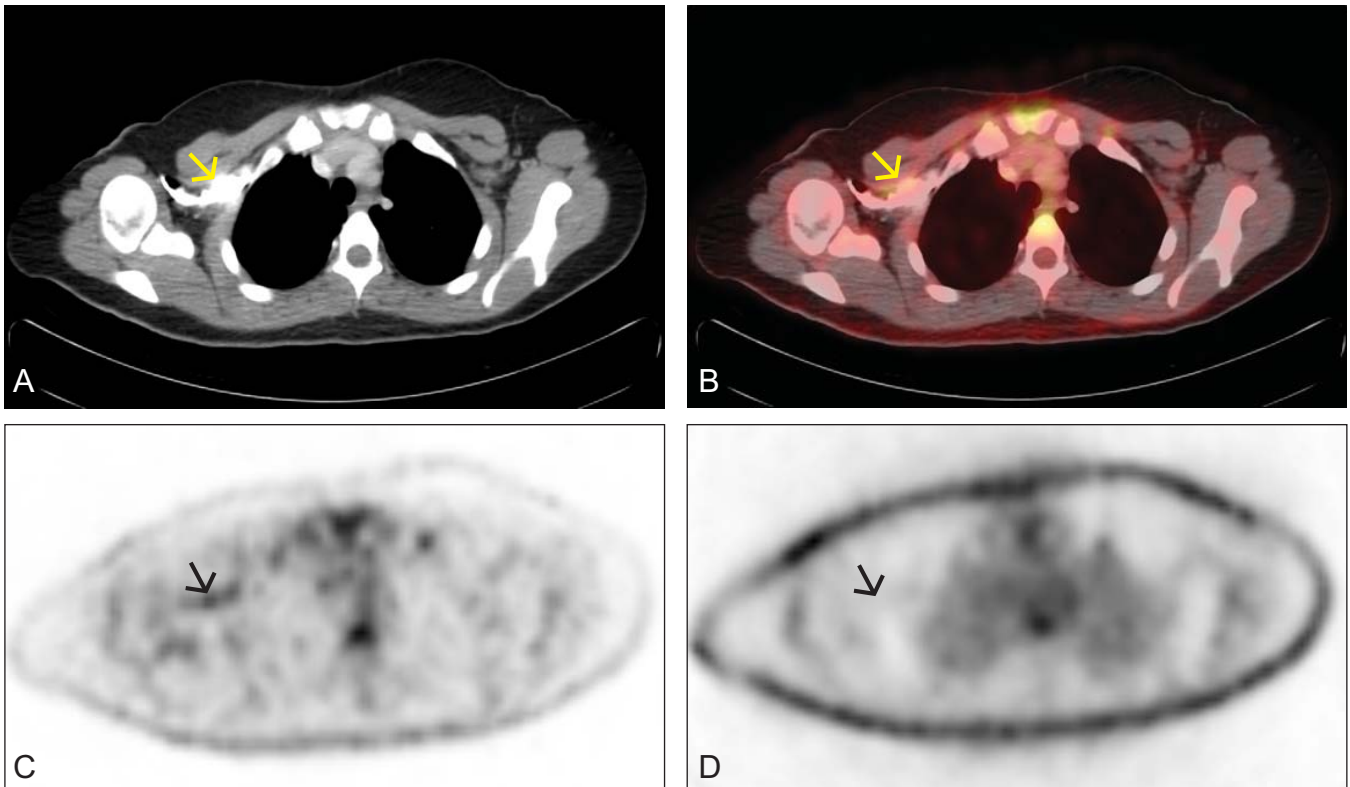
CT axial view with intravenous contrast marked with arrow. B: Fused PET and CT axial image showing FDG avidity over right axilla (SUVmax 2.0 - marked by arrow). C: PET (attenuation corrected image; AC) showing linear shaped FDG uptake in right axilla (arrow). D: PET (Non-attenuation corrected image; NAC) not showing linear shaped FDG uptake in axilla as noted in AC-PET image (arrow).
